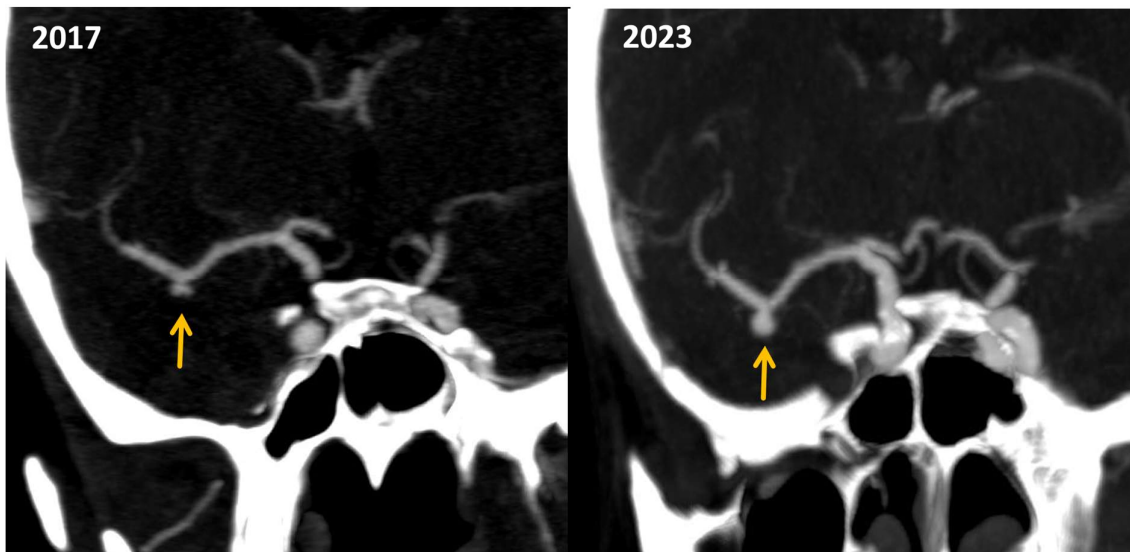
Comparative cerebral CT angiograms in coronal plane (5 years apart) demonstrating the interval increase in size of the right MCA aneurysm (yellow arrow): previously measuring 2.8 x 3.3 mm (HxW), now measuring 3.3 x 4.4mm (HxW).
